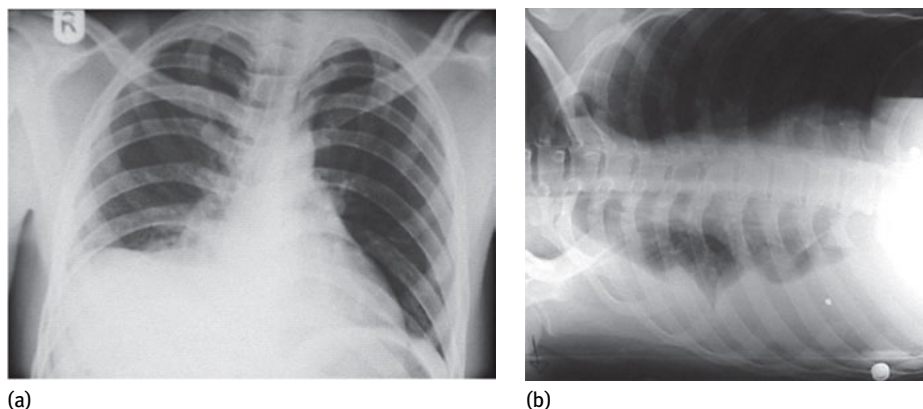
Chest radiograph demonstrating a *subpulmonic* hemothorax, difficult to diagnose on the AP view (a) but becoming apparent on the right side down decubitus view (b).
